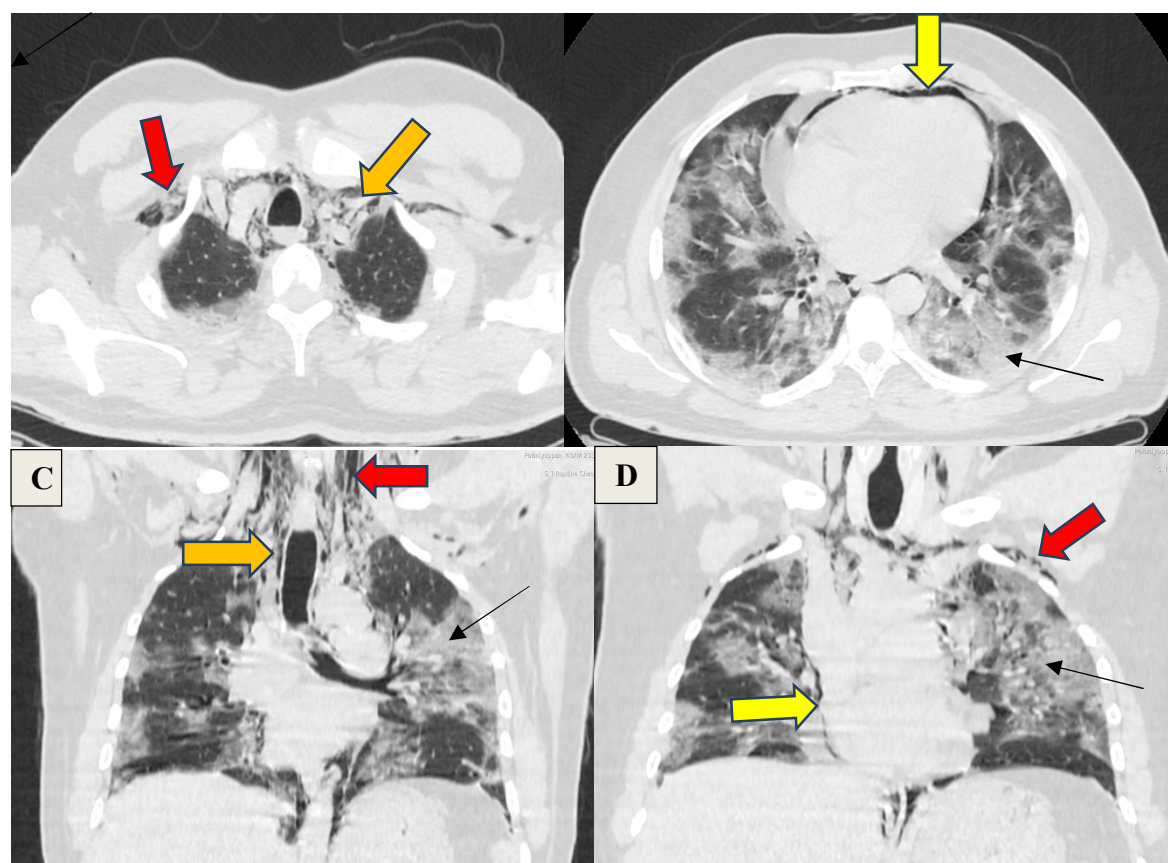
A,B,C&D) a 43 year old male patient, axial and coronal sections of CT Chest showing diffuse ground glass opacities(arrow) and upper neck free air extending to bilateral axilla- subcutaneous emphysema(red arrow), pneumopericardium(yellow arrow) and pneumomediastinum(orange arrow). CORADS-6 Category with CT Severity score of 15/25(moderate)
